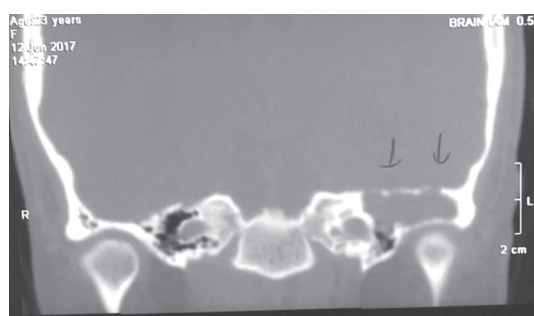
CT mastoid. Shows bony expansion of the petrous bone with soft tissue lesion in the tympanic cavity and attic.
